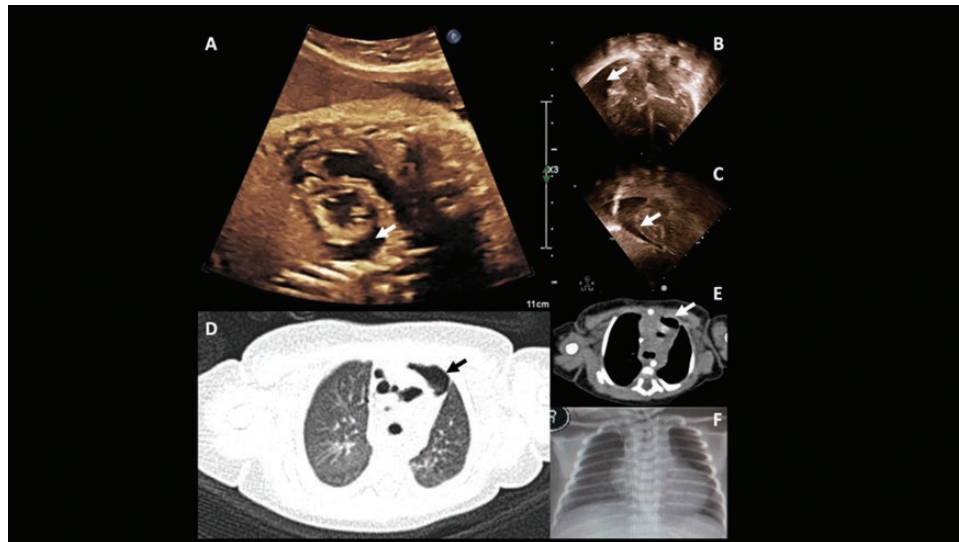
Fetal and postnatal echocardiogram and image exams. (A) Fetal echocardiogram at 32 weeks and 4 days. (B and C) postnatal echocardiogram showing no signs of cardiac tamponade. (D and E) Sagittal chest tomography images showing the “ground-glass pattern” of inflammatory infiltrate in lungs (D) and pericardial effusion at mediastinal region (E). (F) Chest X-ray showing well-expanded pulmonary parenchyma, without infiltrate. Tomography and X-ray images were obtained 2 hours after birth. The arrows indicate pericardial effusion.
